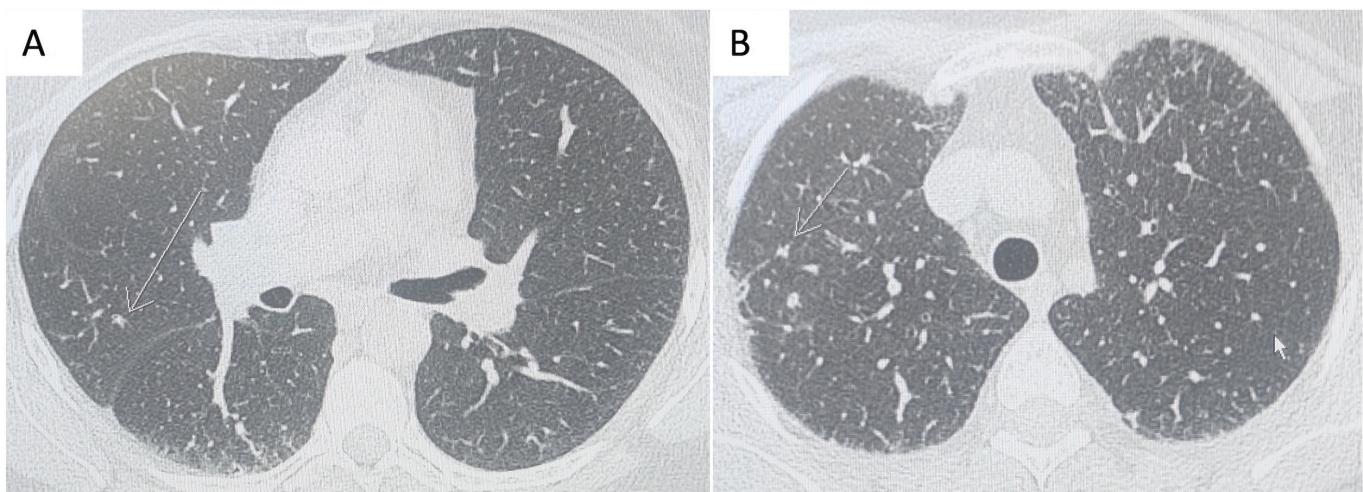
Cross-sectional slices from the high-resolution CT of the chest of our patient demonstrating two distinct nodules in the right upper lobe (see arrows) (A, B).
